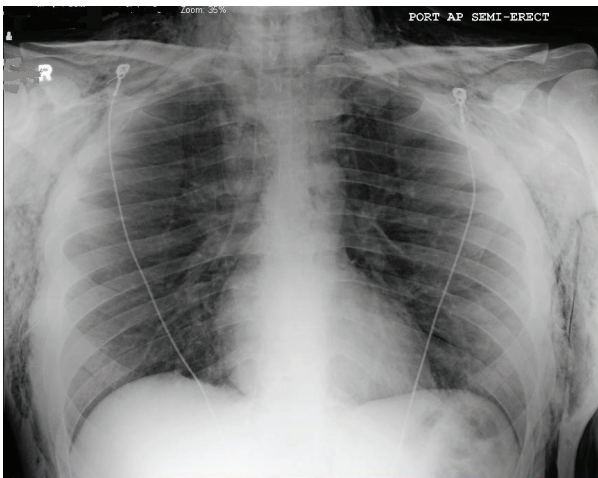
Anteroposterior (AP) view of chest X-ray showing extensive subcutaneous emphysema in the chest and neck.
